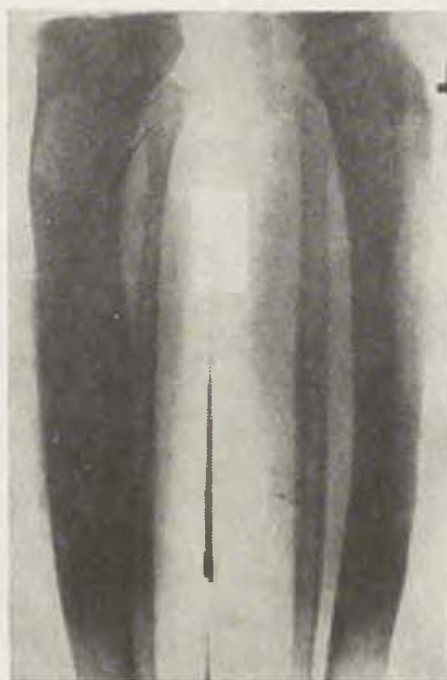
Patient M. X-ray after plasty of osteomyelitic bone cavity in tibia with muscle-skin pedicle flap shows cavity extending over $\frac{2}{3}$ of tibia and marked off by a thin and straight border line.
